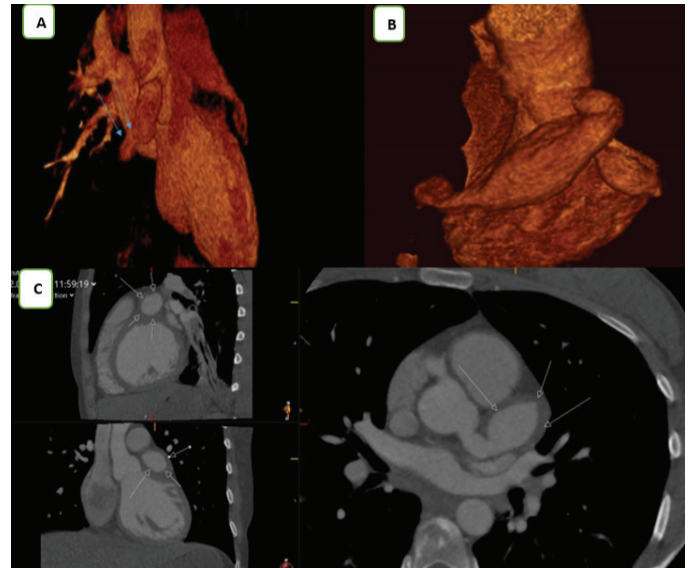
A) The 3D coronary CT angiography shows the aneurysmal and totally occluded image of the RCA, B) 3D Coronary CT angiography: aneurysmal left coronary system (LMCA-LAD and CX) C) The aneurysmal left system appearance with the LAD wall covered by thrombus, indicated by arrows
